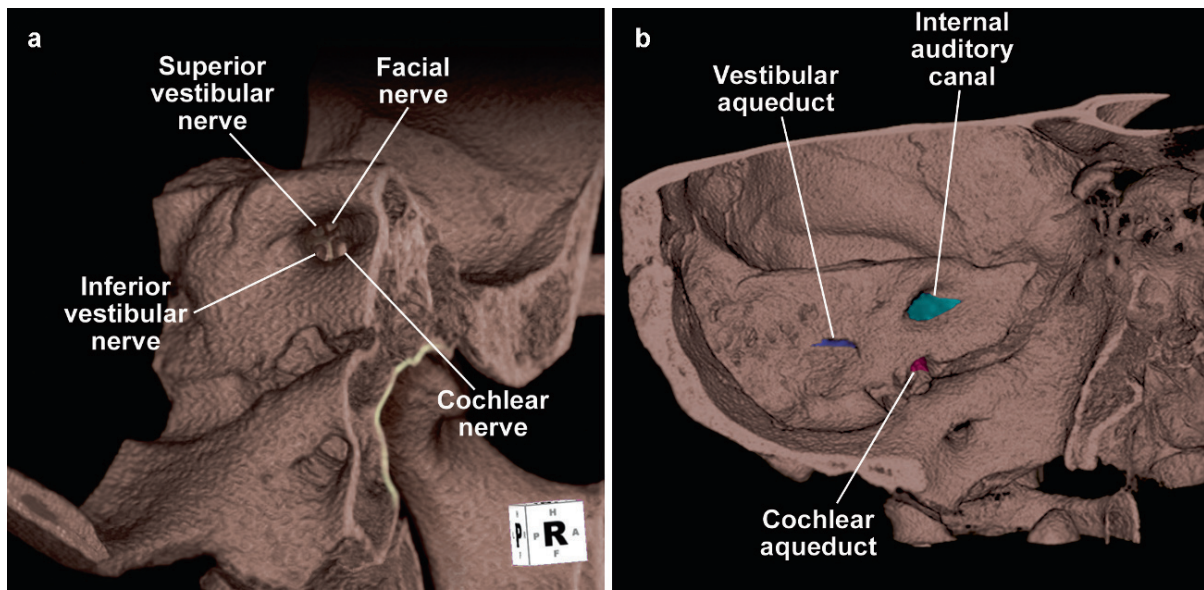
IAC. Multidetector CT reconstruction of the posteromedial surface of the petrous portion of the temporal bone. (a) Exposed view of the left IAC demonstrating nerve exit points at the IAC apex. (b) Posteromedial surface of the temporal bone
